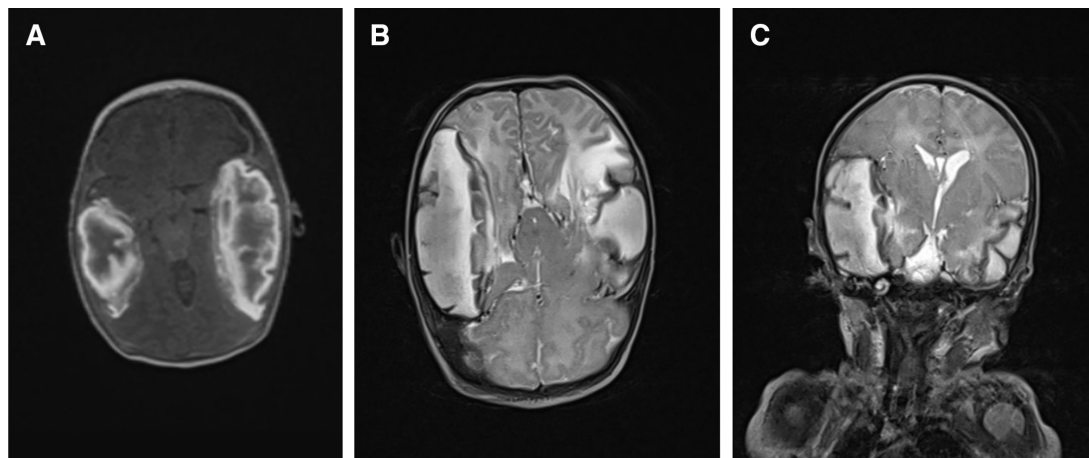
(A:) MRI image showing Aaxial non -contrasted T1WI show multiple extensive hyper intense lesions in the right frontal-temporal regions and left temporal region. (B:) MRI image showing Aaxial non -contrasted T2WI show multiple extensive hyper intense lesions in the right frontal-temporal regions and left temporal region. (C:) MRI images showing Ccoronal T2WI image shows significance effacement of the right lateral ventricles due to lesion mass effect. NB: T1W1 is a Magnetic resonance imaging term referring to the spin-lattice relaxation time and used to provide the consistency of a tissue
